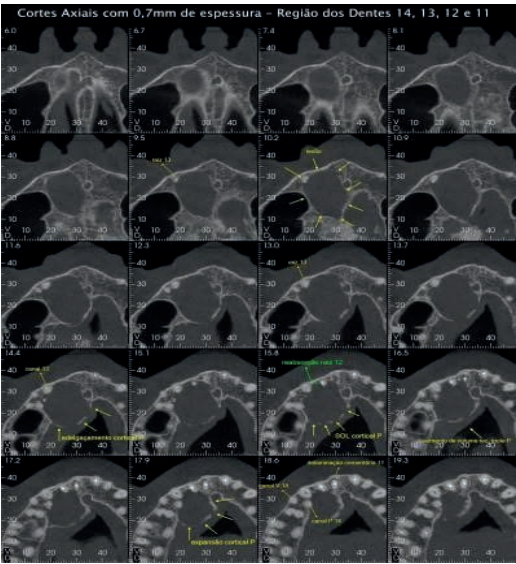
Cone beam computed tomography of the maxilla - Axial sections
